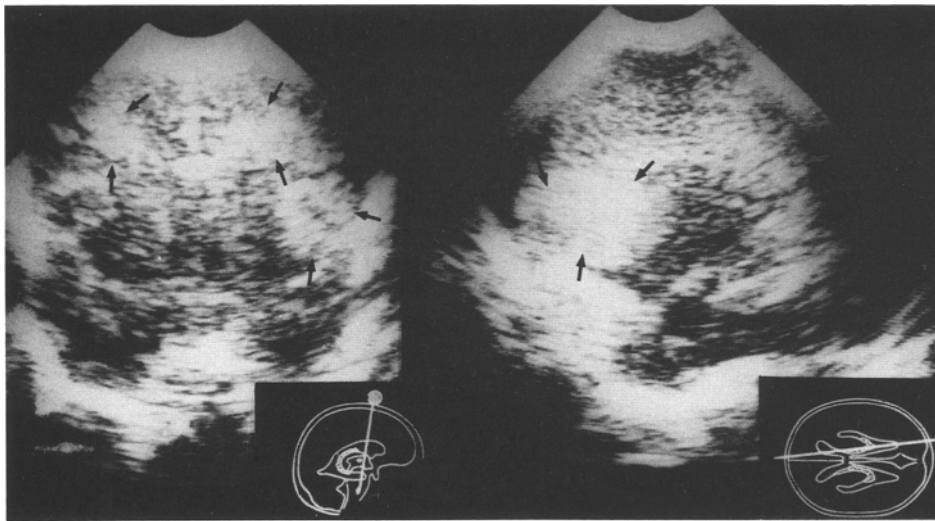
Patient 7. Ultrasound: zones of high echodensity frontobasally, pre-centrotemporally and in the areas of the lateral fissures
